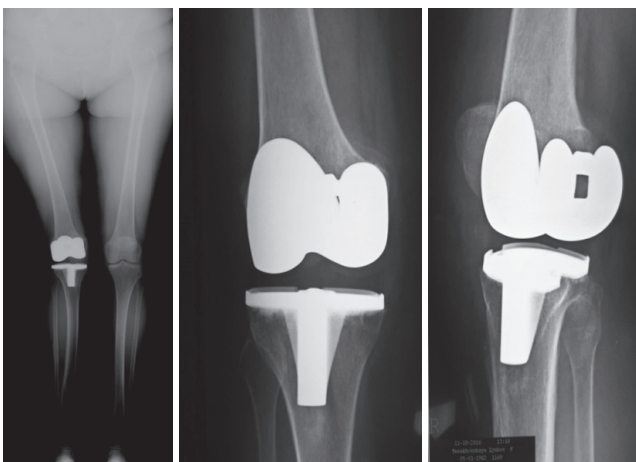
X-rays confirming medial ligament instability and incorrect frontal positioning of components
